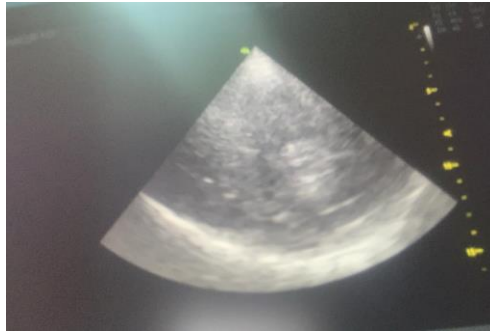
Hyperechoic images in cerebral parenchyma founded with cerebral ultrasound through temporal window
